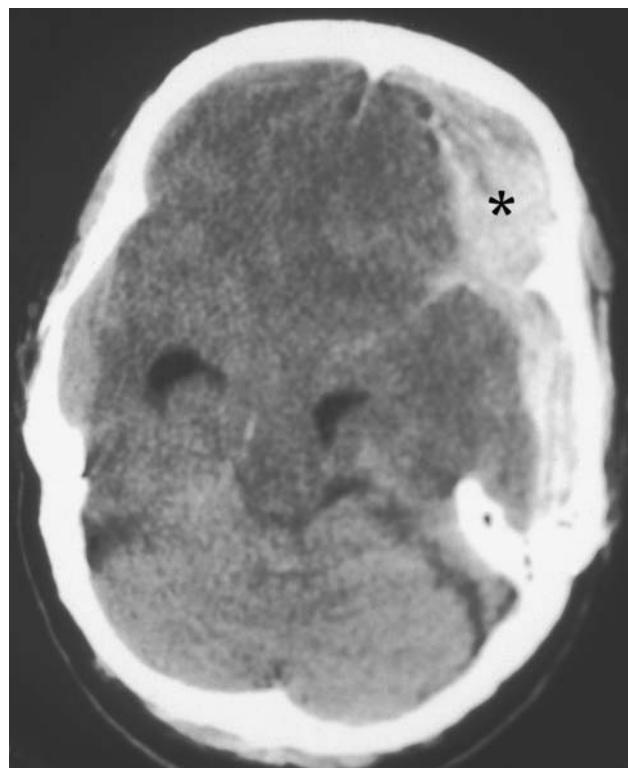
A CT scan of an acute subdural hematoma (*asterisk*) over the left frontal and parietal lobes. A subdural hematoma presents with a crescentic shape that is restricted to one side of the brain. With an acute subdural hematoma, the blood appears hyperdense in relation to the brain.
